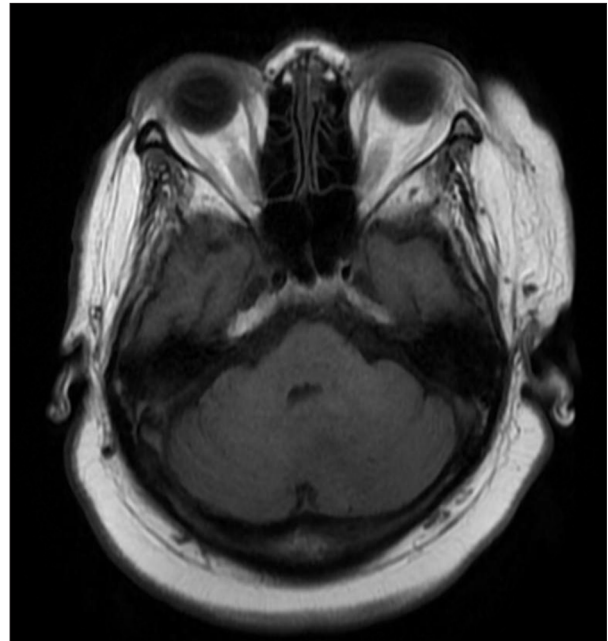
Magnetic resonance imaging of the brain (T1 Axial image) showing low signal intensity on T1.
